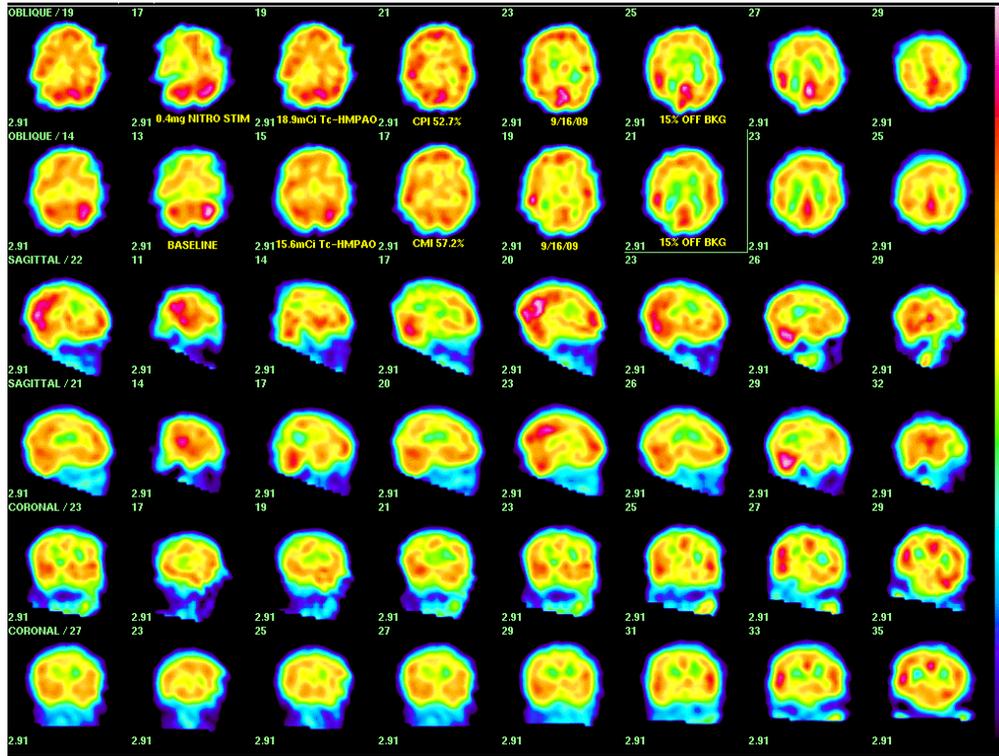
(above) A 44 year-old insulin-resistant (IRS) woman with hypertriglyceridemia and difficulty controlling her weight suffers from migraine and syncopal spells after a motor vehicle accident. She has borderline stage 3 renal insufficiency with glomerular filtration rate 56 ml/min at the time of brain SPECT shown on the right which shows minor abnormalities including a wedge-shaped right frontal defect (axial 29), posterior right parietal minor deficit (Axial 25) and decreased cerebral flow reserve index, $CFi = 52.7\% - 57.2\% = -4.5\%$ (normal $> 1.0\%$). Correction of CFi for renal insufficiency would make CFi even more abnormal, approx. -7.5% .
